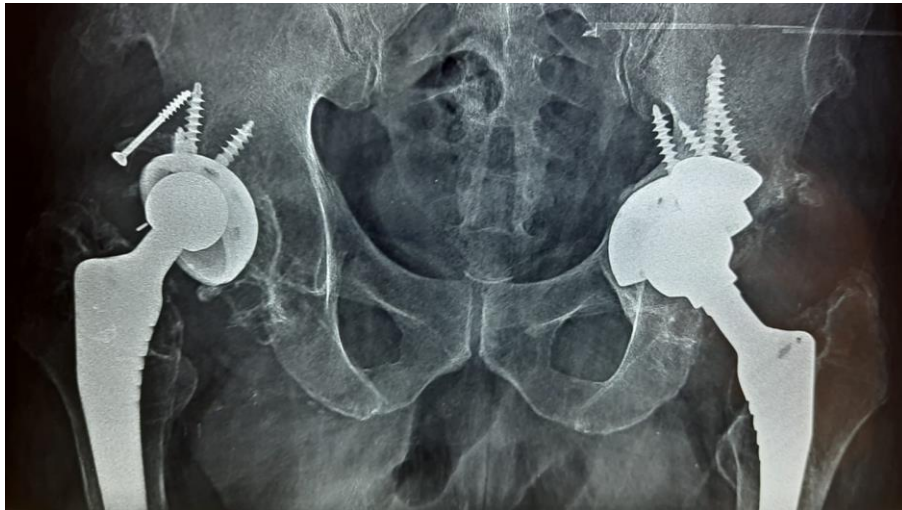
follow up x-ray after 6 months
